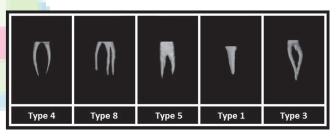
Examples of the reconstructed cone beam computed tomography images of the most observed root canal types (the types were put in order from left to right according to the most observed to least)
